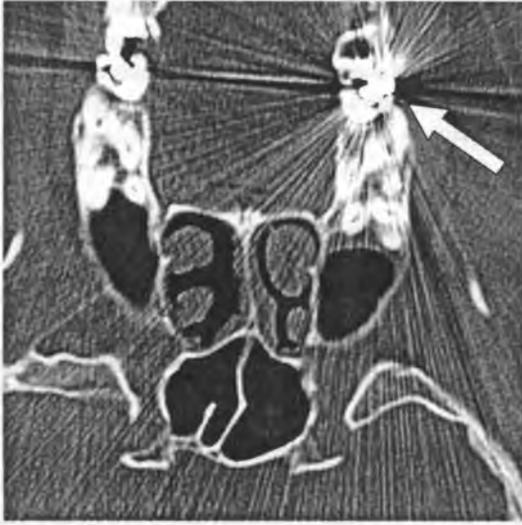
Streak artifacts generated by dental amalgam (arrow) deteriorating the CT image of paranasal sinuses
